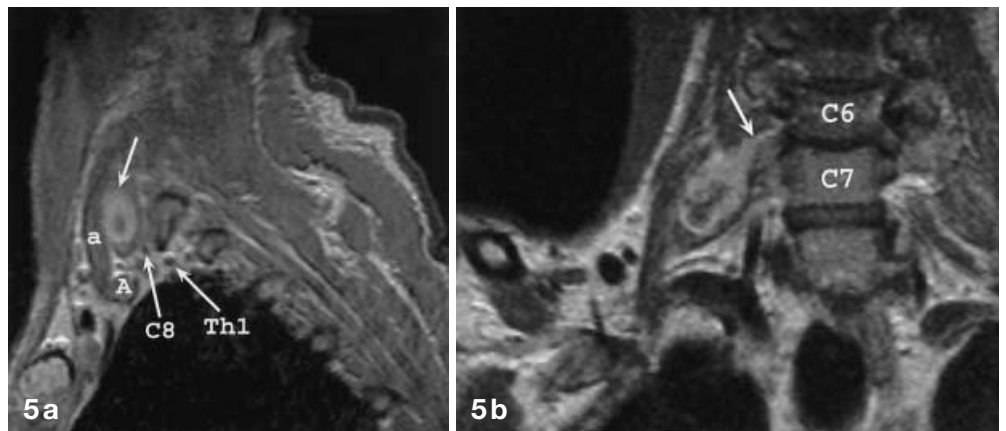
A patient with a schwannoma of C7. a Sagittal contrast-enhanced T1-weighted image shows an enhancing tumor (*arrow*) in the interscalene triangle which displaces the anterior scalene muscle (*a*) anteriorly. The ventral rami of the roots C8 and Th1 can be discerned. A subclavian artery. b Coronal contrast-enhanced T1-weighted image shows the fusiform enhancing tumor, which tapers toward the intervertebral foramen C6–C7 (*arrow*)
